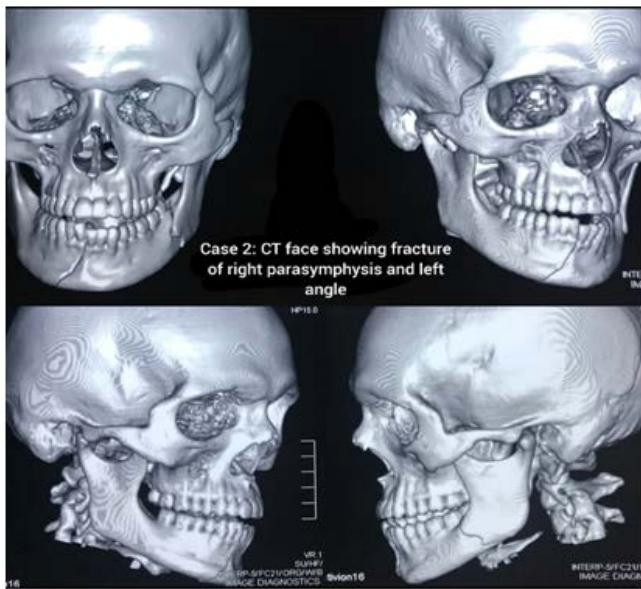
CT Fracture of right parasymphysis and left angle with teeth involved in the fracture line
